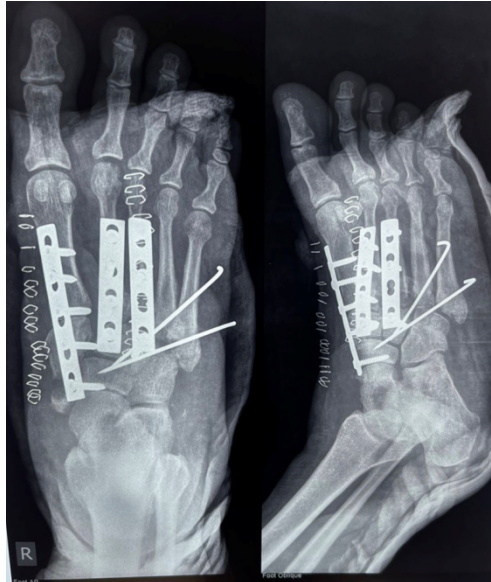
Immediate postoperative radiograph confirming restoration of midfoot alignment and stable internal fixation.
